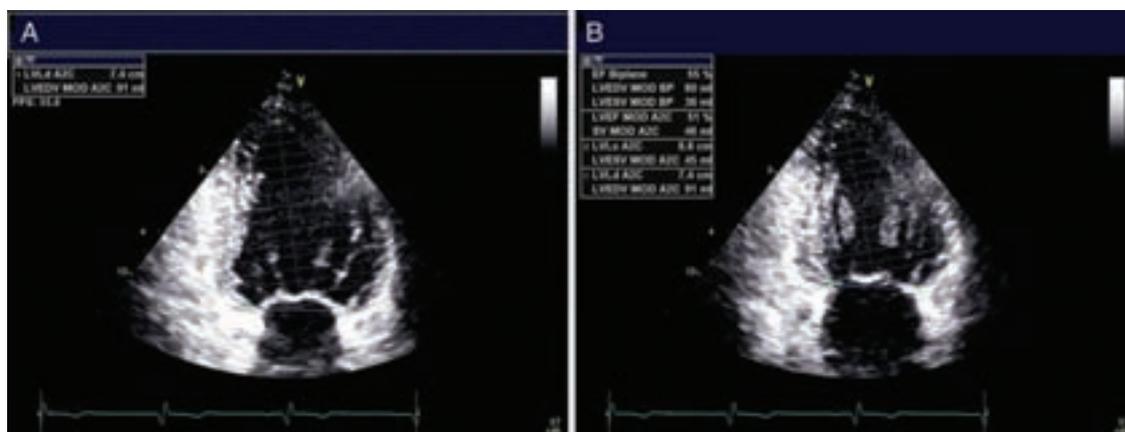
Calculation of LVEF using the biplane Simpson's method. (A) Apical two-chamber view obtained at end-diastole. (B) Apical two-chamber view obtained at end-systole.
